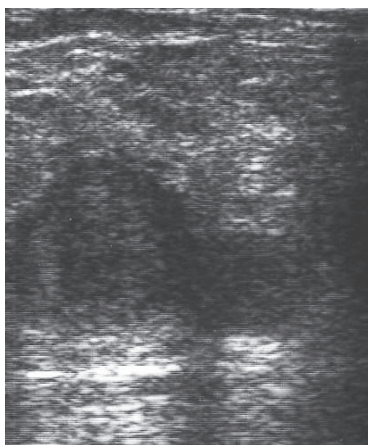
Ultrasonography showed numerous clots forming in the right popliteal vein to the ipsilateral femoral vein. The clots could be clearly recognized.
